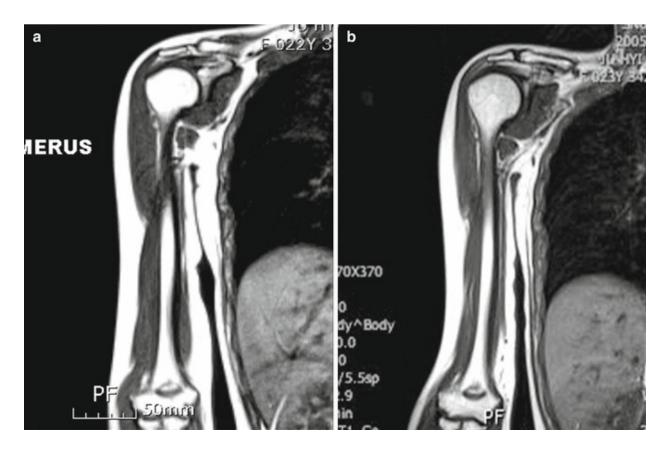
MRI showed the reduction of deltoid muscle volume by 17 % at 2 months after injection of 50 U of BOTOX® per side. (a) Before. (b) After
